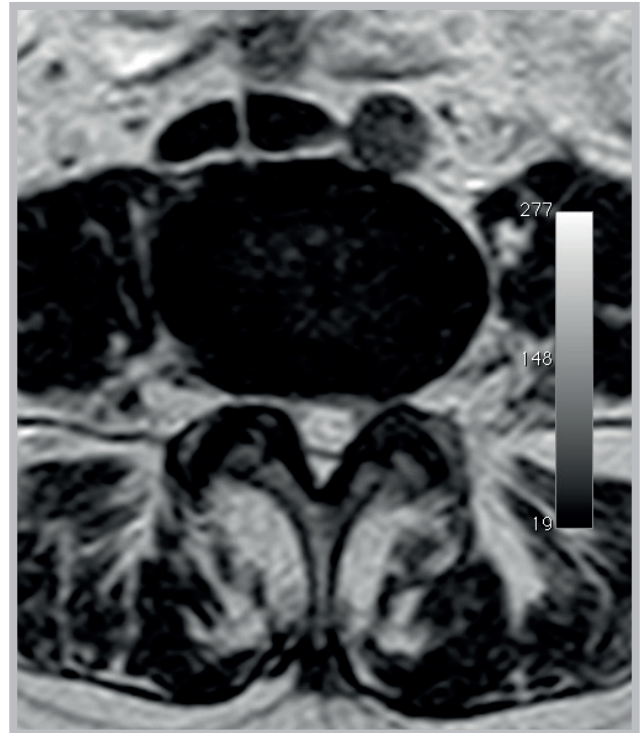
MRI demonstrates the reduction of disc compression on the nerve root
